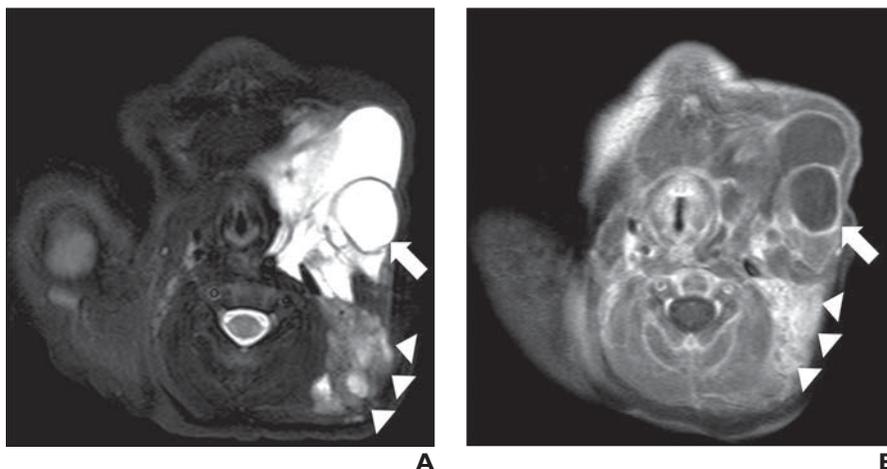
2-month-old girl with neck swelling because of mixed macrocystic and microcystic lymphatic malformation. A and B, Axial T2-weighted fat-saturated (A) and postcontrast T1-weighted fat-saturated (B) MR images show transspatial left neck mass, with both macrocystic anterior (*arrows*) and solid-appearing microcystic posterior (*arrowheads*) components.
